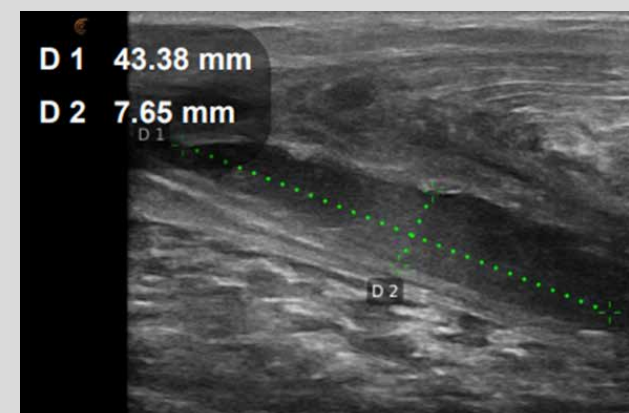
Ultrasound 5 days after injury
